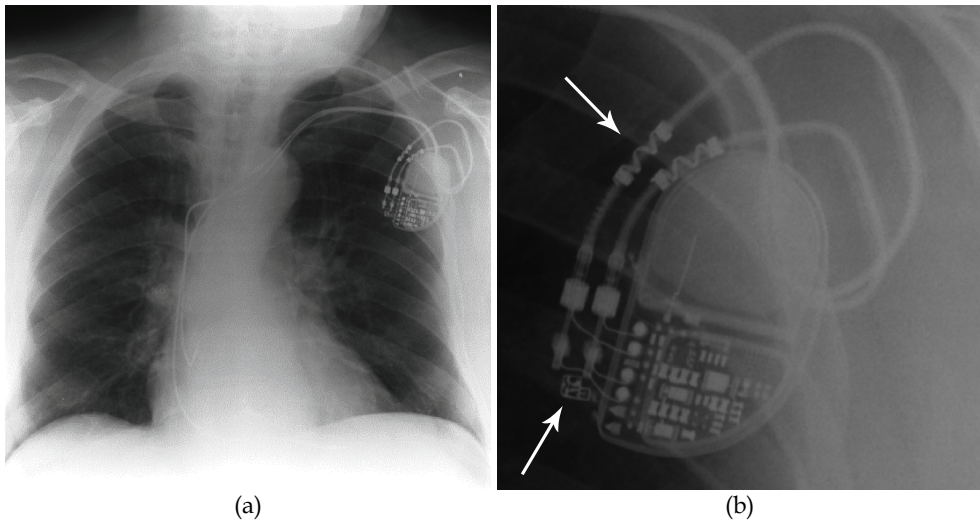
Plain film chest X-ray allows visual confirmation of lead placement and integrity, implantable pulse generator (IPG) position, and MR conditional radiopaque markers (arrows).
